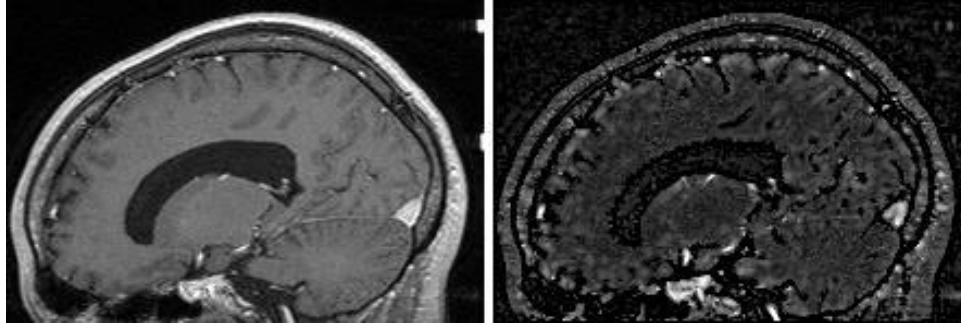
a. Original, and b. Line filtered MR images (Figures are reproduced from [7])
